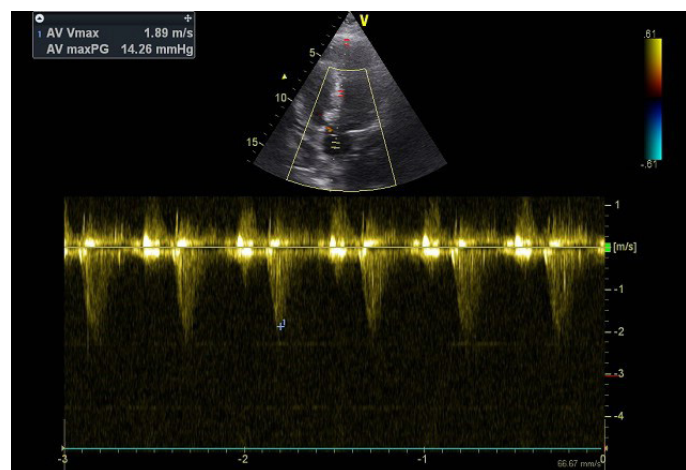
Apical five-chamber view, pulsed wave Doppler showing insignificant pressure gradient at aortic valve level.
